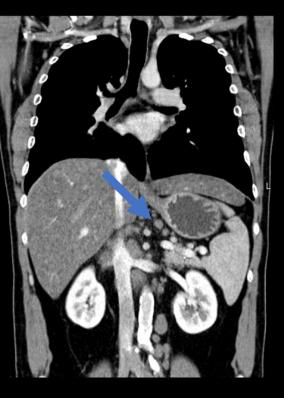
Axial and Coronal enhanced CT scans. Retroperitoneal enlarged lymph nodes.
